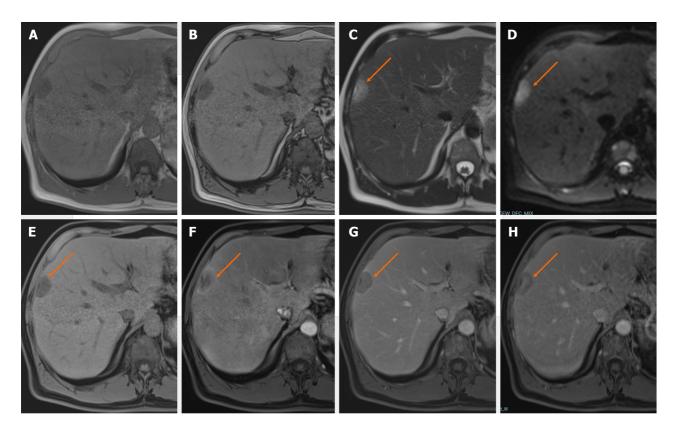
Liver metastases from prostate adenocarcinoma. In Gd-EOB-magnetic resonance imaging of a 52-year-old male patient. A: On in-phase images, there is a focal hypointense liver lesion; B: On out-of-phase images, the lesion persists hypointense compared to the healthy liver parenchyma; C: On T2-weighted images, the lesion appears slightly hyperintense (orange arrow); D: Diffusion restriction in the lesion on diffusion-weighted imaging (orange arrow); E: Before contrast administration, the lesion is hypointense (orange arrow); F: The lesion appears hypervascular due to peripheral rim-like hyperenhancement during the post-contrast late hepatic arterial phase (orange arrow); G: The lesion is hypointense on the portal-venous phase compared to the healthy liver parenchyma (orange arrow); H: On the hepatobiliary phase, low signal intensity of the lesion due to washout is observed, especially in the peripheral areas (orange arrow).
